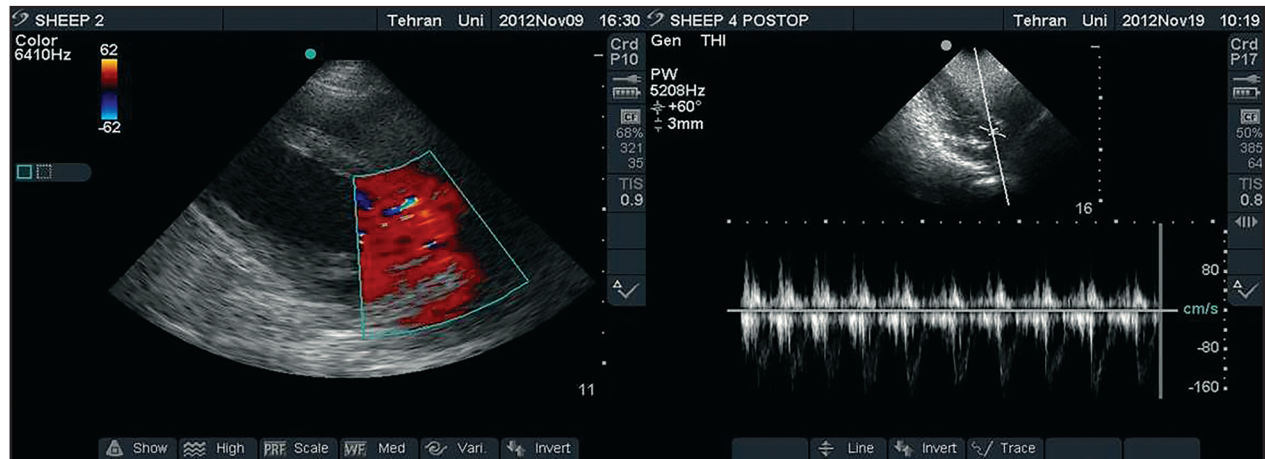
Collor (left) and spectral (right) Doppler of native aortic valve.
